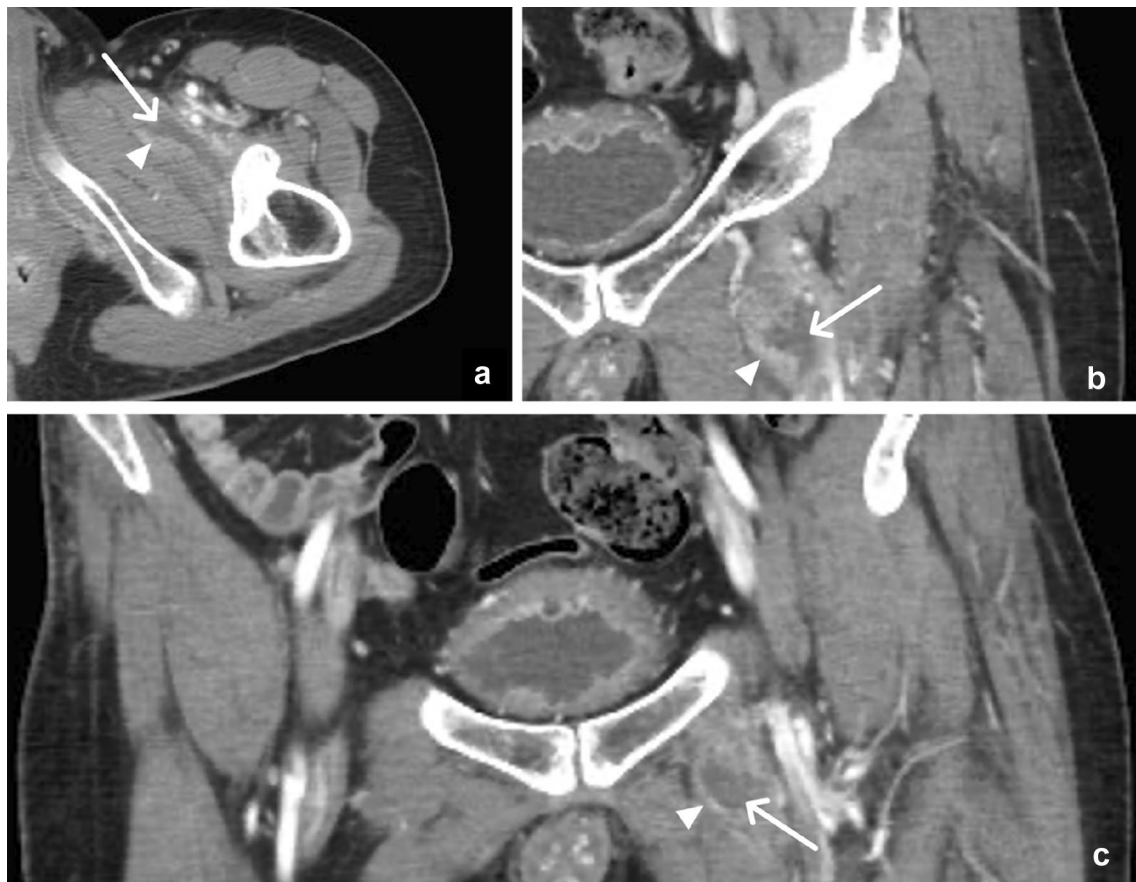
45-year-old male with left pectineal muscle myonecrosis. Axial (a) and coronal (b, c) contrast-enhanced CT images demonstrate peripheral enhancement (arrowheads) surrounding a centrally hypoattenuating (arrows) left pectineus muscle
